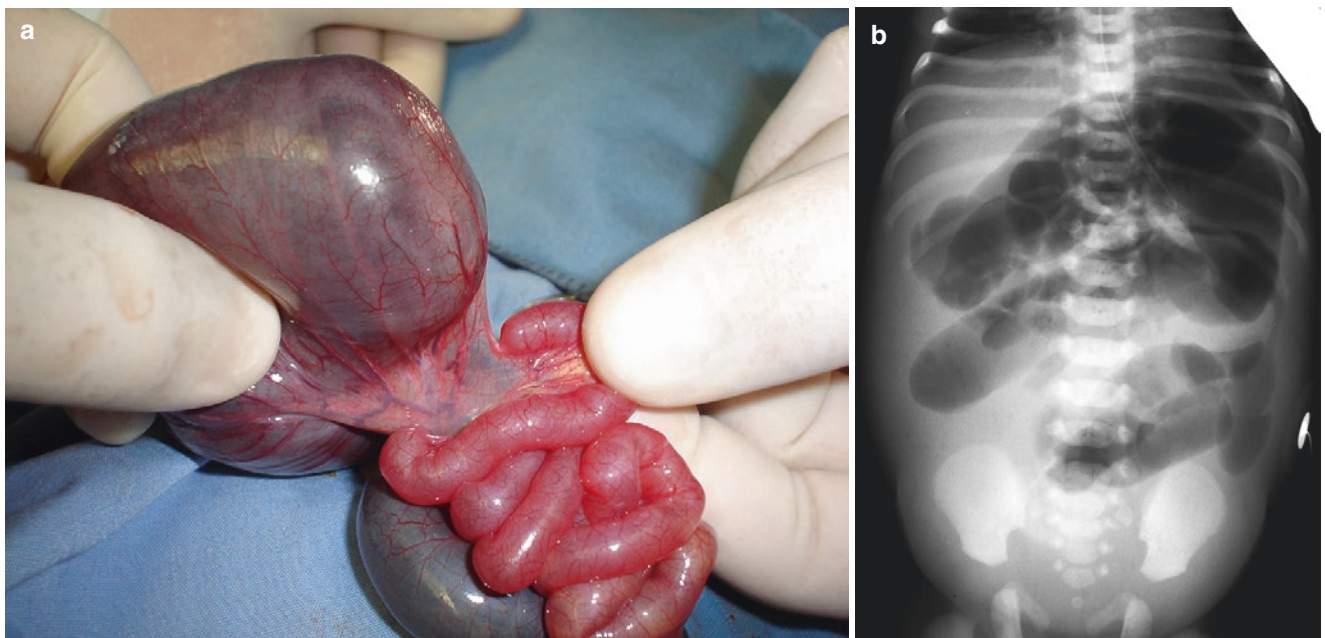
(a) Clinical photograph—Atresia of small bowel. Note the discrepancy in size. There is a fine atretic fibre joining the two making this a type I atresia (b) Plain X-ray showing a jejunal atresia. Nasogastric tube in situ. (c) Plain X-ray of the abdomen showing gross neonatal abdominal distension. The distended loops make it difficult to tell if
